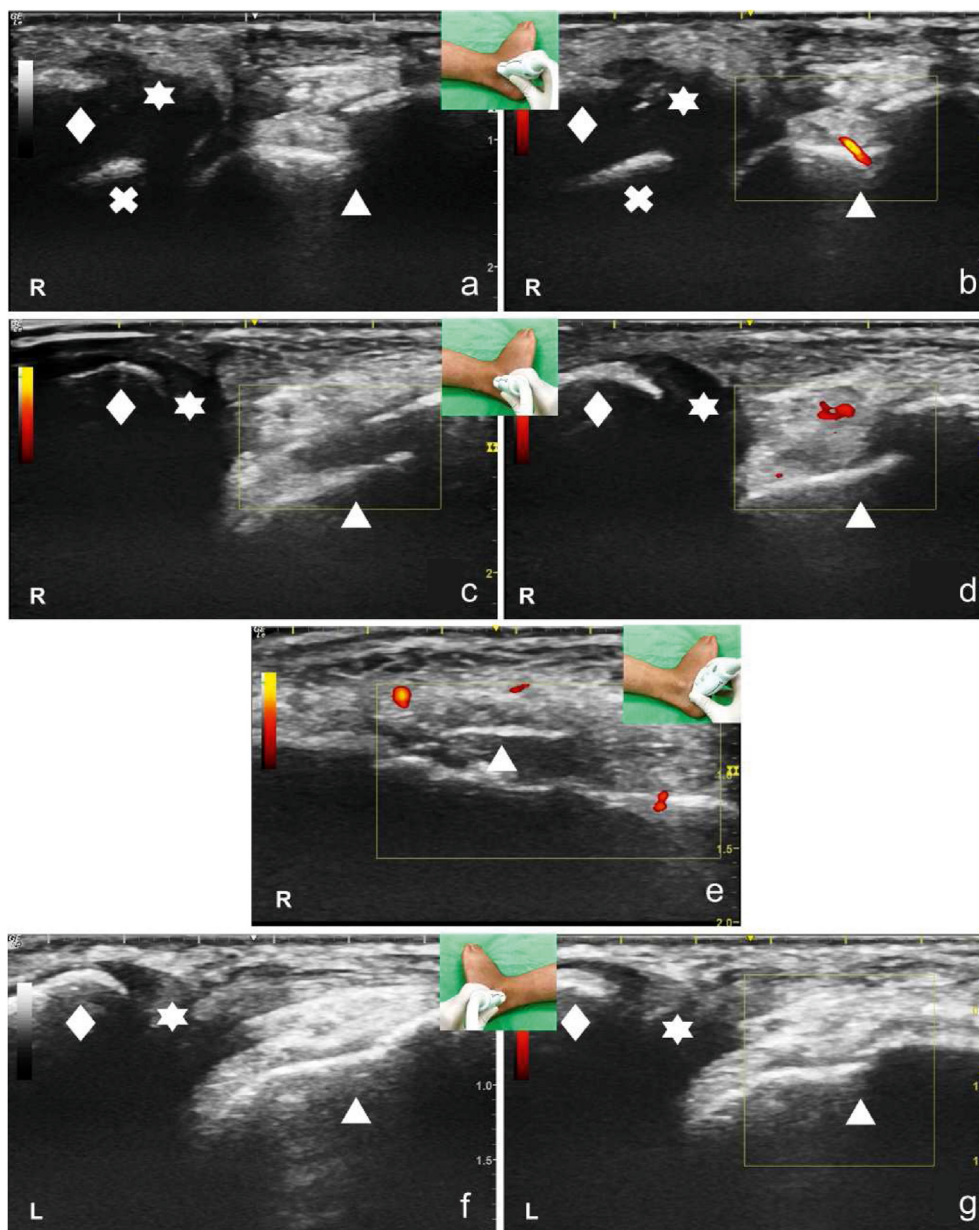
Ultrasonography shows the fibula (diamond), unossified epiphysis (star), talus (cross), and calcaneus (triangle). We placed the probe below lateral malleolus, parallel to the Achilles tendon, which shows: (a) cortical irregularity with a step-off lesion at the right posterolateral calcaneus (triangle); and (b) some periosteal reaction and increased power Doppler flow at the right posterolateral calcaneus (triangle). Then, we moved the probe more posteriorly of the foot and found (c) a cortical irregularity with a step-off lesion at the right posterolateral calcaneus (triangle); and (d) increased power Doppler flow at the right calcaneofibular ligament; and we rotated the probe 90° and showed (e) a thin avulsed bone fragment located above the right posterolateral calcaneus (triangle), with increased power Doppler flow surrounding it. Finally, we placed the probe on the left ankle, which showed (f) a normal structure of the left calcaneus (triangle) and (g) no power Doppler flow evidence at the left posterolateral calcaneus (triangle) compared with (c) and (d).
